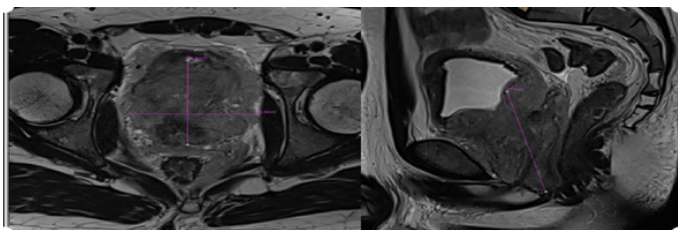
Prostate MRI. Multi-parametric MRI of the prostate gland, in T2 axial and T2 sagittal planes, showing prostatomegaly measuring 6.6 cm × 7.1 cm × 8.7 cm (AP × T × CC), with volume of 212 mL
